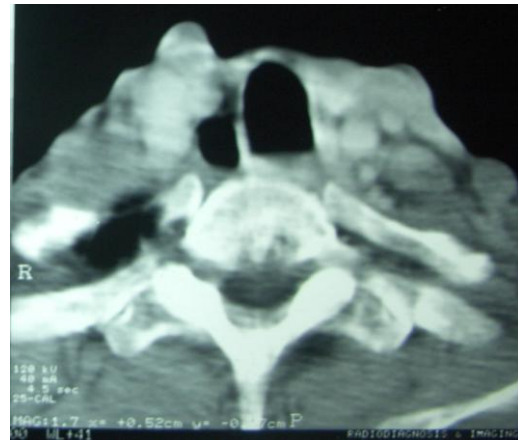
CT scan of the neck showing metastasis to the cervical vertebra
